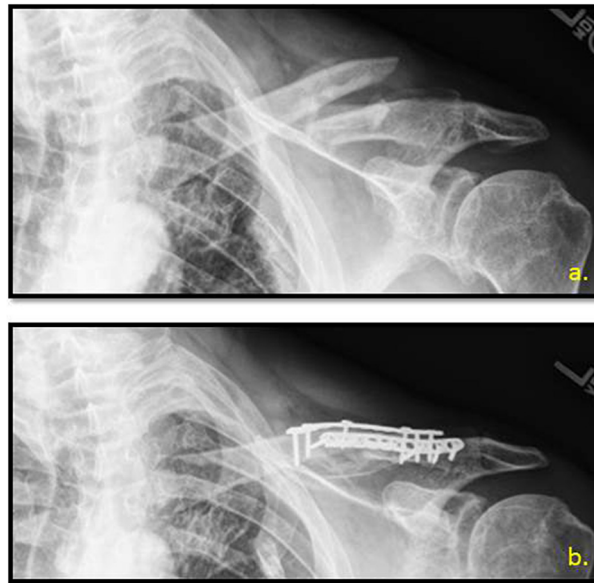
a.) Case 2 preoperative AP radiograph showing a comminuted displaced midshaft clavicle fracture with significant shortening. b.) Case 2 AP radiograph at 3 months postoperatively showing a well-aligned, healing midshaft clavicle fracture.
